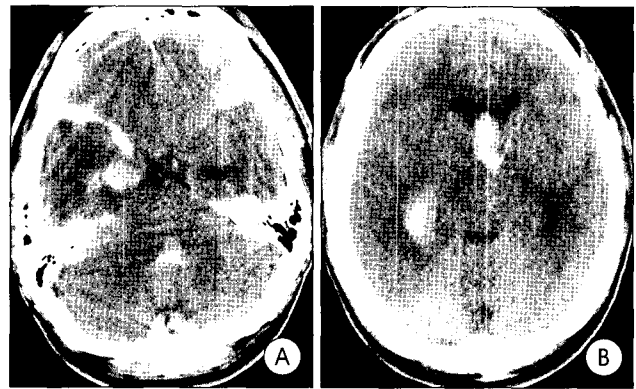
A, B : Brain computed tomography scans of patient 2 taken after neurological deterioration, showing intraventricular hemorrhage and subdural hematoma with significant mass effect.
